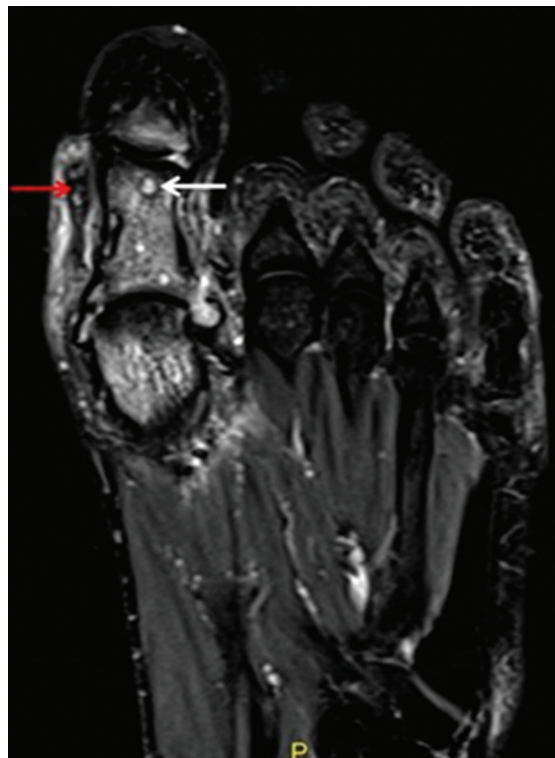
Non-contrast fat-saturated T2-weighted coronal MRI of the foot showing discrete as well as conglomerate small rounded lesions in intraosseous marrow. It also shows soft tissue with peripheral hypointense rim (white arrow) and central hypointense focus (red arrow), which suggests dot-in-circle sign. Also, note the marrow edema involving the phalanges of the great toe and head of the first metatarsal.
